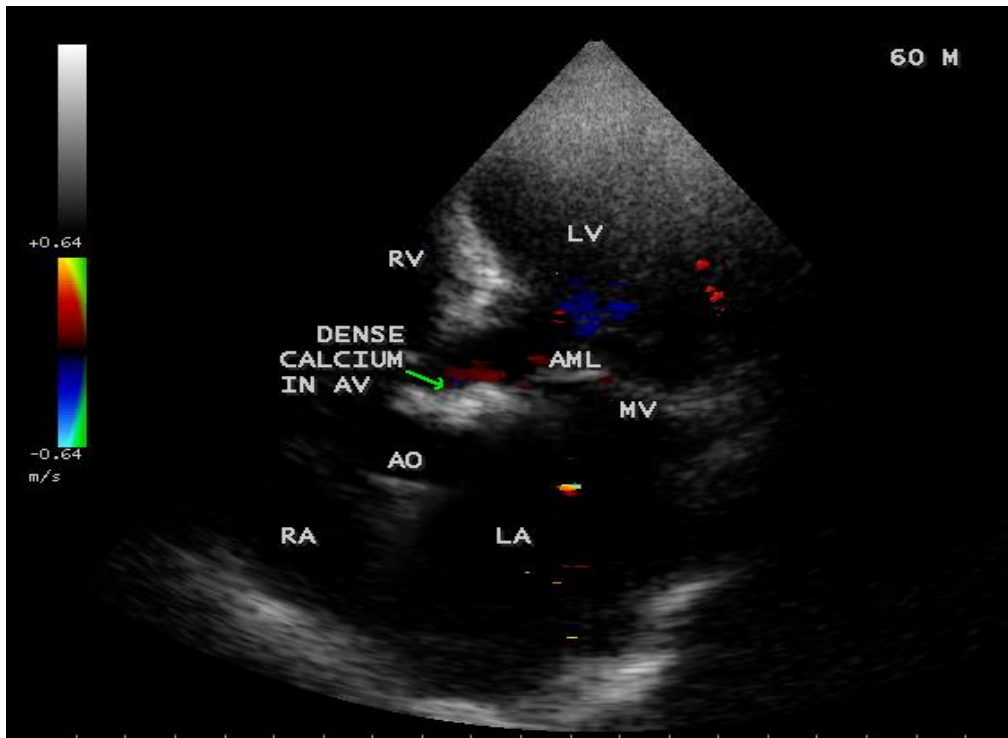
Parasternal long axis view showing the calcification of anterior mitral leaflet in a 60-year old male.
